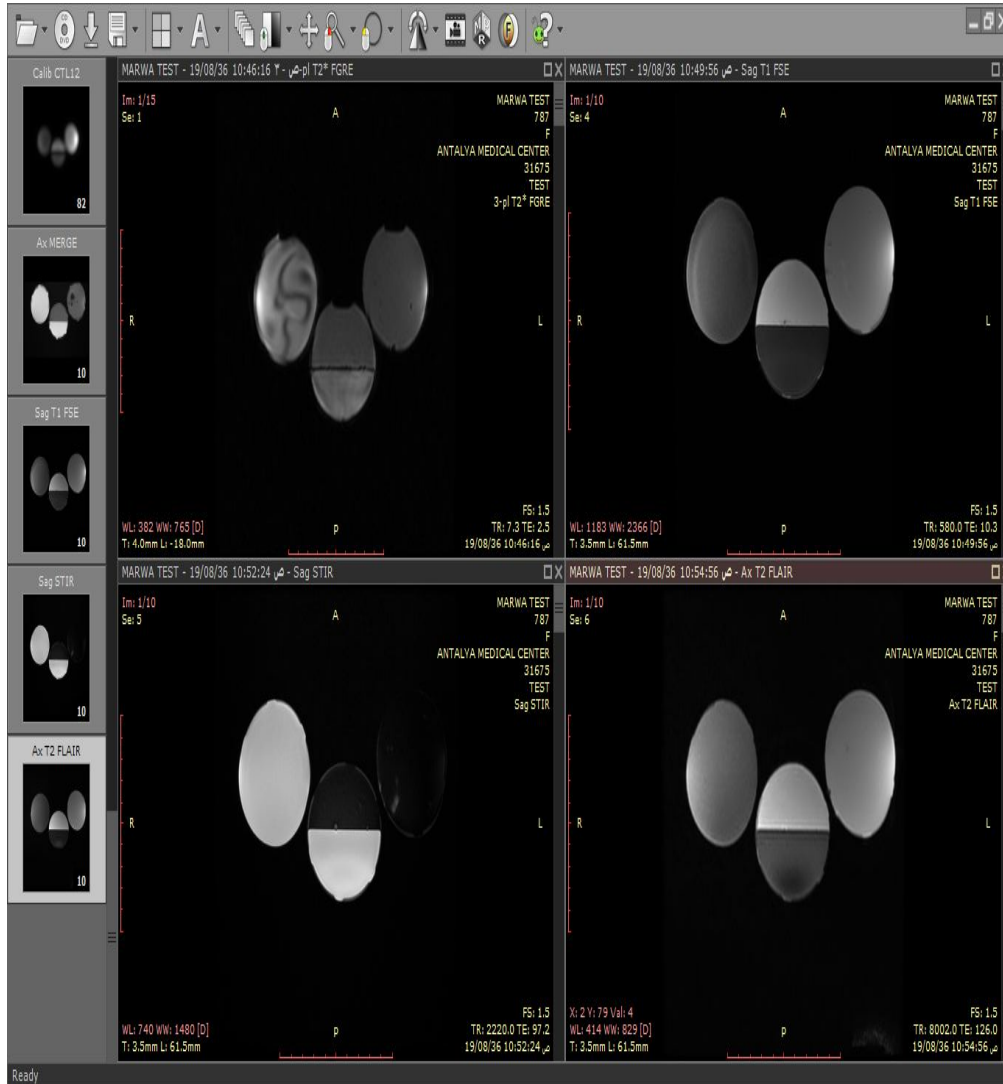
image techniques (T1, T2, STIR, FLAIR) taken by GE MRI 1.5T in Antalya medical center.
